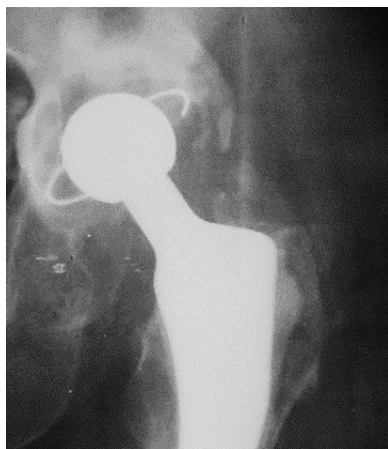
Left hip X-ray showing 2nd degree heterotopic ossification.*
